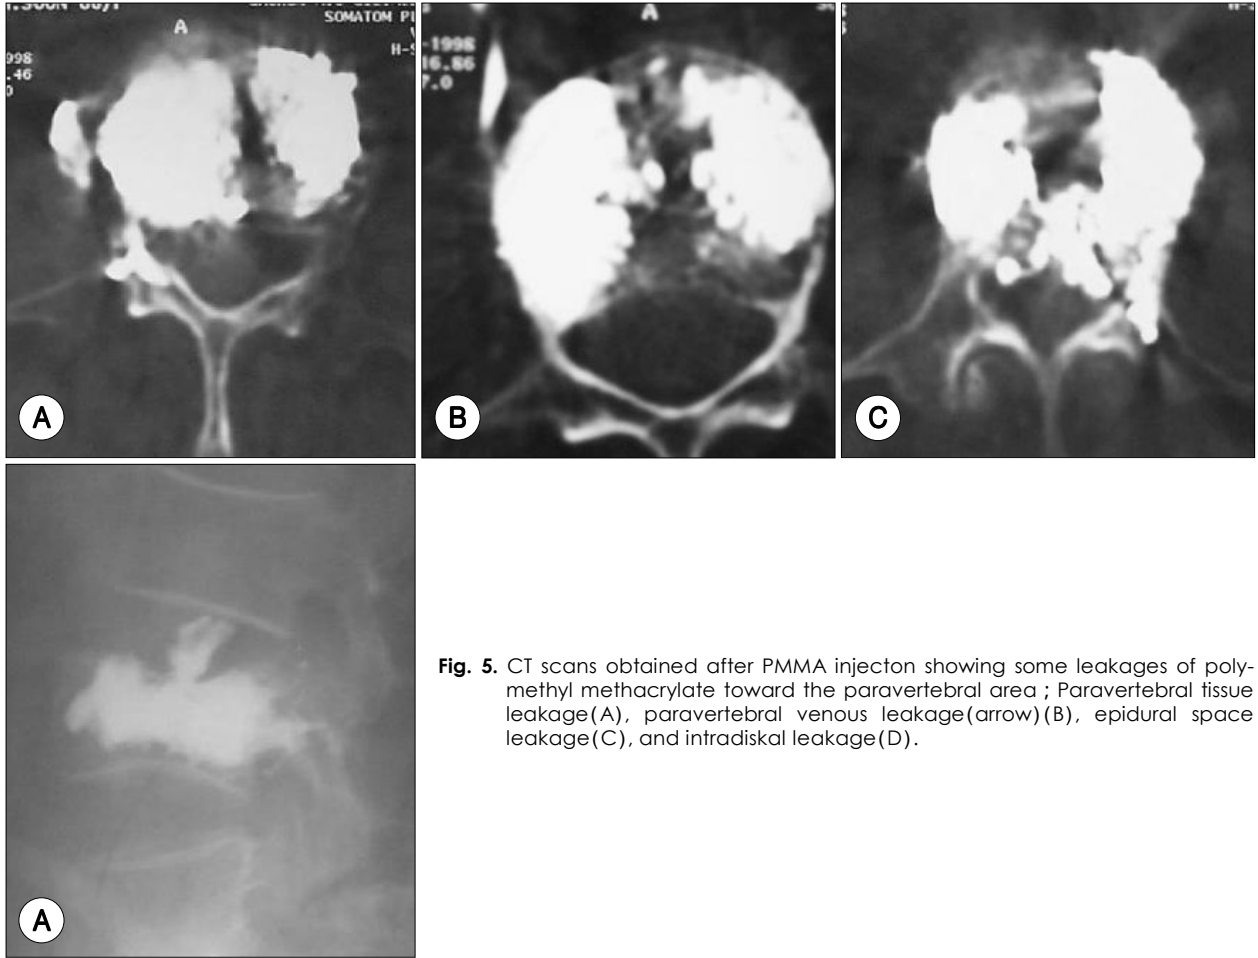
CT scans obtained after PMMA injection showing some leakages of polymethyl methacrylate toward the paravertebral area ; Paravertebral tissue leakage(A), paravertebral venous leakage(arrow)(B), epidural space leakage(C), and intradiskal leakage(D).
